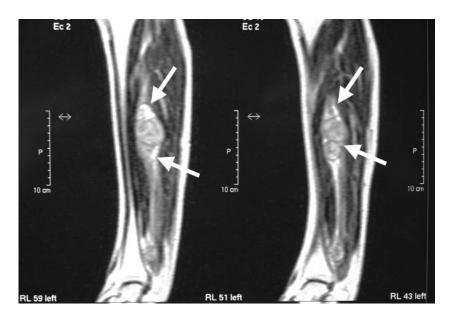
Coronal T2-weighted image of the leg showing an isolated multilobular schwannoma (white arrow) in a patient with schwannomatosis
